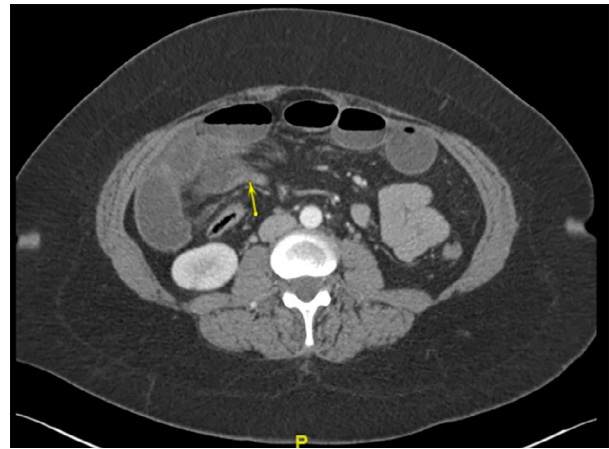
A patient with a history of tubal ligation carried out more than a decade ago showed symptoms of small bowel obstruction. The computed tomography scan shows dilated distal jejunal loop with abrupt transition, suggestive of small bowel obstruction. Yellow arrow indicates the transition point.
